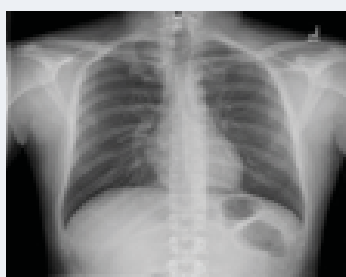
Chest X-ray PA views showing bilateral apical pleural thickening more on left side more than on the right.
